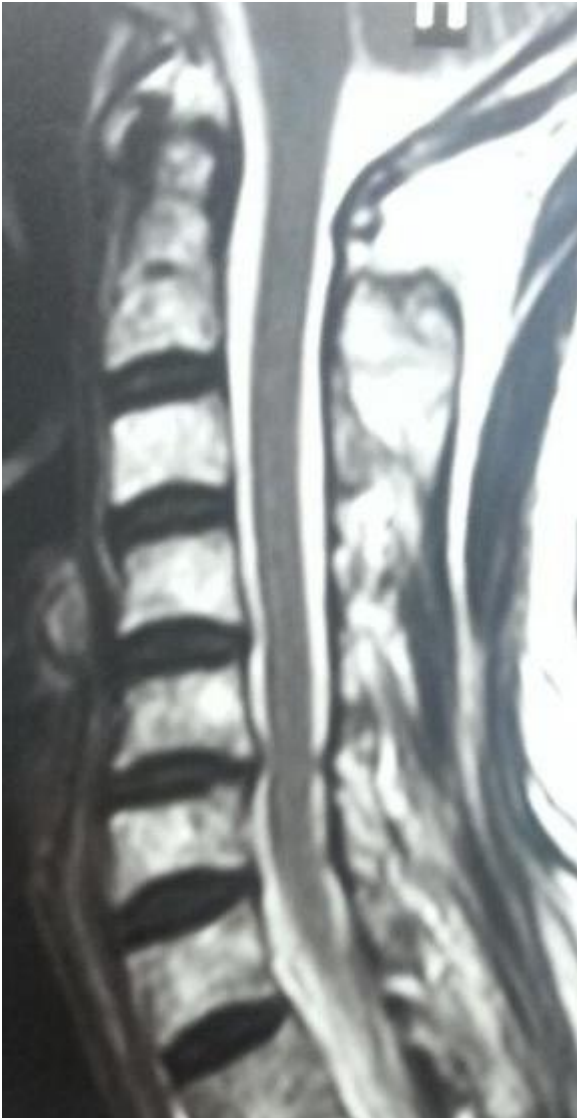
Magnetic Resonance Imaging T2 sequence of cervical spine, showed compression of spinal cord at C 5-6 level
